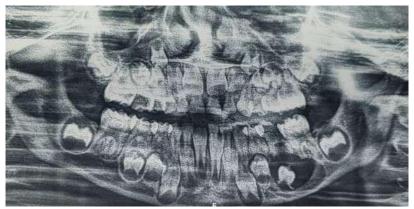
Orthopantomogram revealing unilocular radiolucency with the crown of unerupted left second premolar 35.
